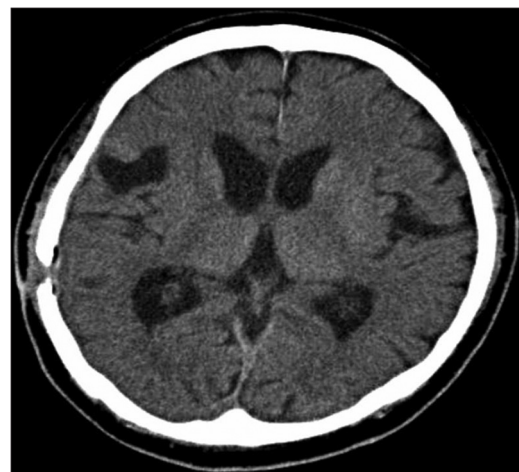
Axial noncontrast follow-up CT brain 6 months postoperatively shows complete resolution of initial right-sided CSDH and stable right frontoparietal gliosis
